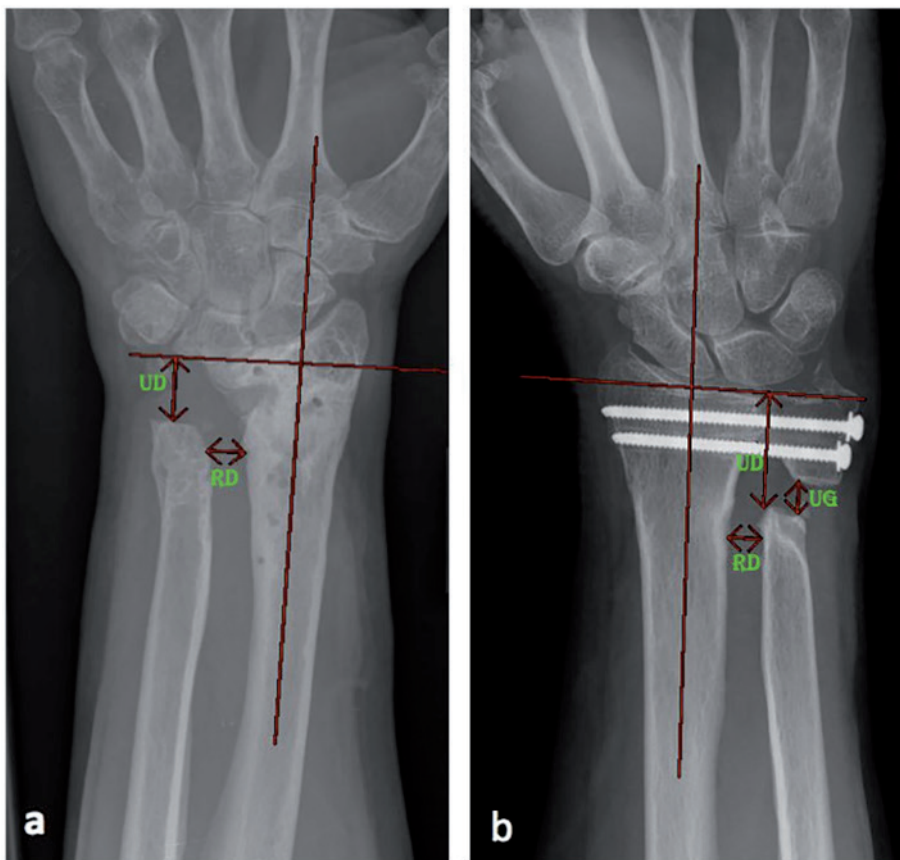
Measurement on postero-anterior radiograph in (a) Darrach and (b) Sauvé-Kapandji. Note. UD = ulnar distance; RD = radioulnar distance; UG = ulnar gap.
